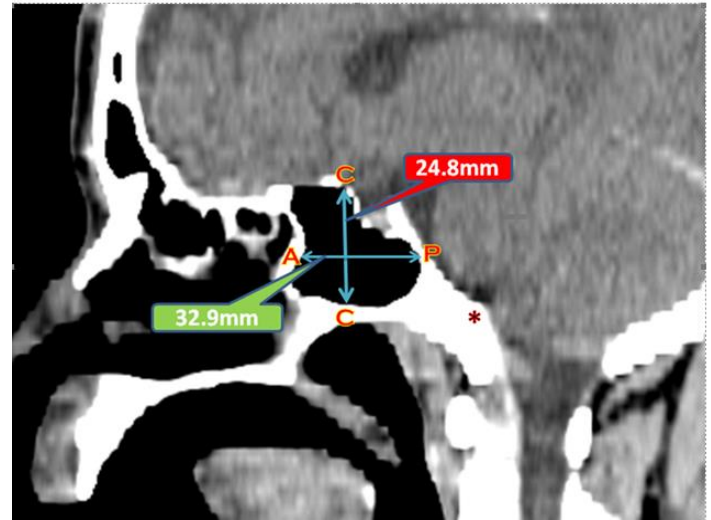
Sagittal slide of sphenoid sinus CT of a 72-year-old male showing landmarks of measurements. AP = Anteroposterior diameter, CC = Craniocaudal diameter. Clivus bulge (elevation) is marked*, found in 5% of normal individuals.^{2,5}
